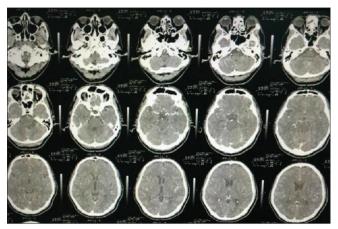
Axial head computed tomography scan with contrast at admission indicated meningitis
